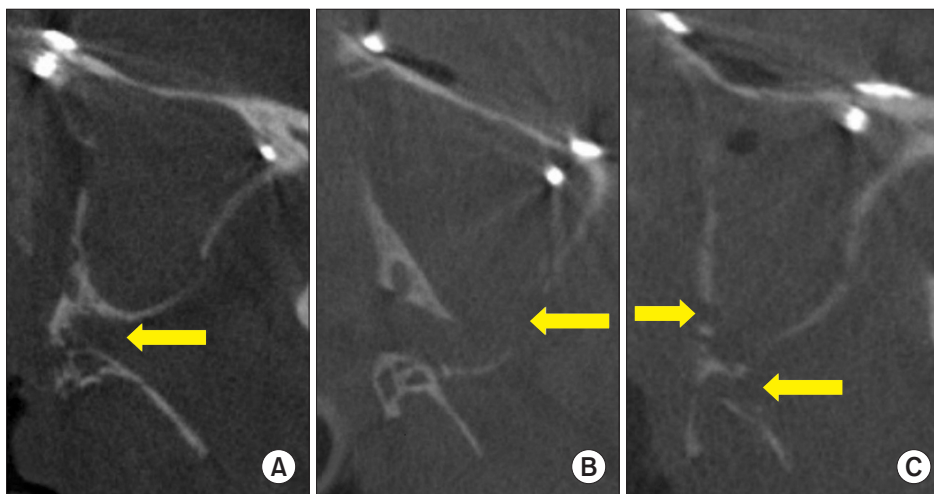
Pterygomaxillary junction (PMJ) cutting type in postoperative cone-beam computed tomography. A. Type I: the cutting line within the PMJ (arrow). B. Type II-1: the posterior wall of maxillary sinus detached (arrow). C. Type II-2: a part of posterior wall of the maxillary sinus (left arrow) and pterygoid (right arrow) fracture occurred after PMJ separation.
